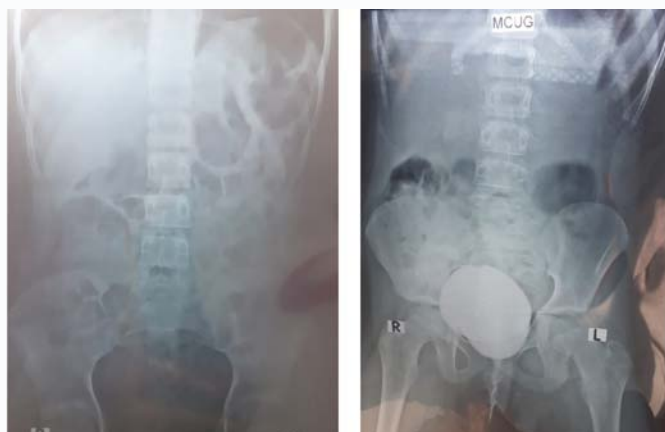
Abdominal radiograph with left colon fecal loading, excessive gas and colonic distention and a normal MCUG.
